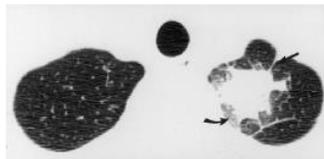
20-year-old man with bronchocentric granulomatosis following bone marrow transplant for acute lymphoblastic leukaemia. High-resolution CT (1 mm collimation) demonstrates a 2.5 cm spiculated mass in the apical segment of the left upper lobe. Areas of ground-glass opacification (curved arrow) and smooth interlobular septal thickening (straight arrow) are noted.
